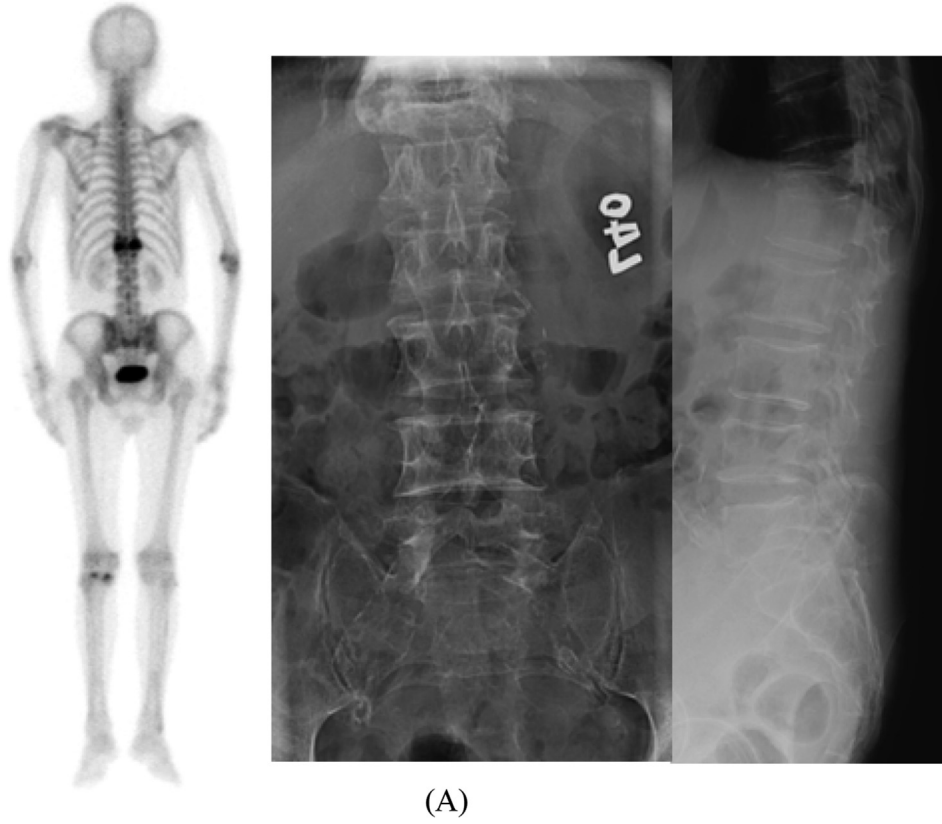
(A) L1 cleft sign on plain film and hot uptake on bone scan. (B) Low density on T1 and high density on T2.
